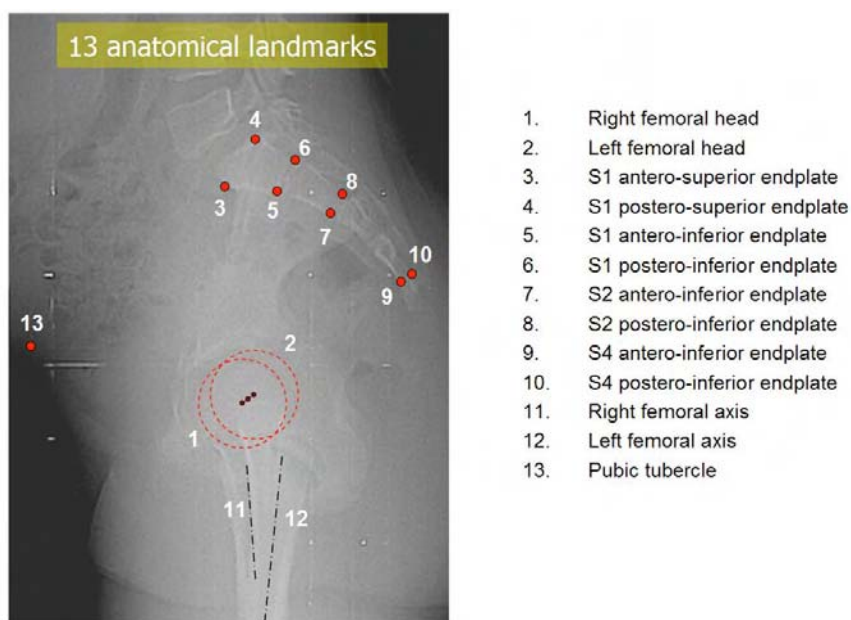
Anatomical landmarks digitized on the LAT radiograph
